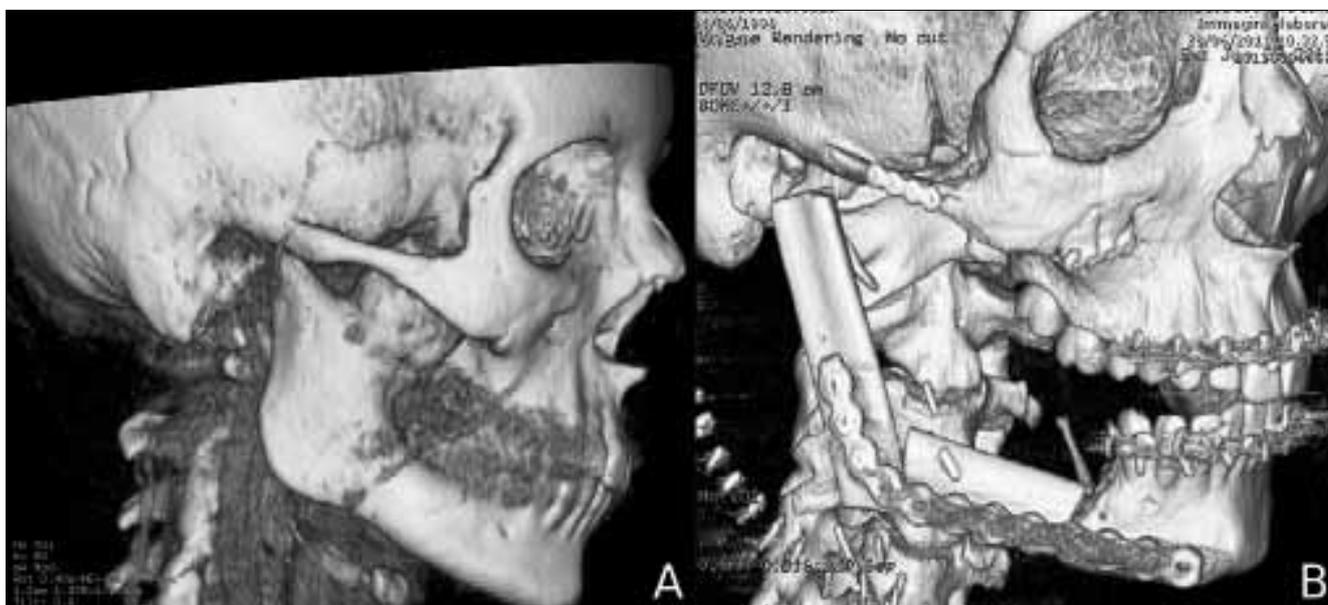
Case 2. (A) Pre-operative CT scan showing the neoplasm, which extends through the whole right mandibular ramus and the posterior part of the body. (B) Post-operative 3D-CT scan showing microvascular mandibular reconstruction using a fibula free flap.
